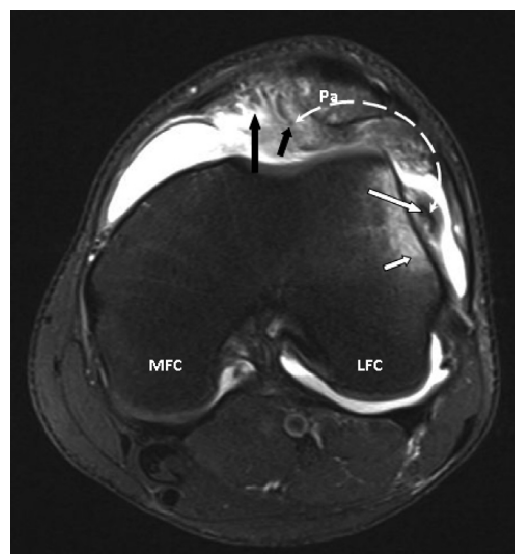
Knee MRI axial proton density fat suppressed view showing evidence of lateral patellar dislocation and osteochondral fracture of lateral femoral condyle from re-entry injury. Pa – patella (laterally subluxed); MFC – medial femoral condyle; LFC – lateral femoral condyle; long black arrow – MPFL tear; short white arrow – bone; oedema lateral femoral condyle; long white arrow – displaced osteochondral fragment; short black arrow – bone oedema inferomedial patella; double ended dashed curved arrow – direction of lateral patellar dislocation and relocation resulting in 're-entry injury'; 're-entry injury' – patella dislocates laterally. As it relocates tangentially over the lateral femoral condyle, both the lateral femoral condyle and inferomedial medial border of patella are at risk of chondral damage on impact.
